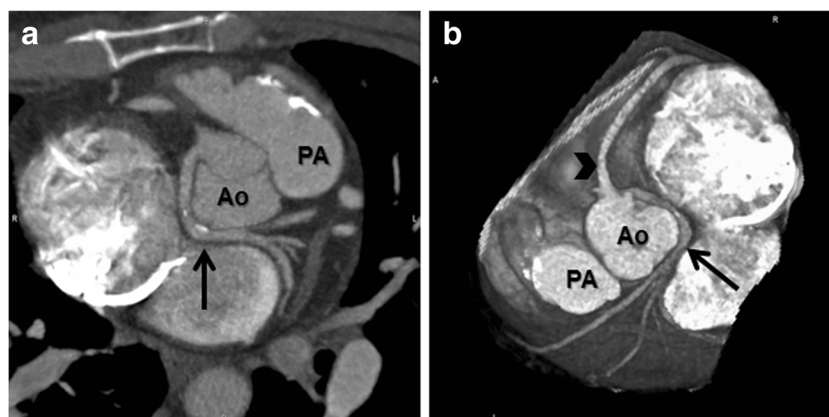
A 35-year-old man was referred for coronary CTA after a non-gated chest CT suggested ACAOS. a The maximum intensity projection image demonstrates the left main coronary artery arising from the right sinus of Valsalva with a posterior (retroaortic) course (*arrow*). Calcified
